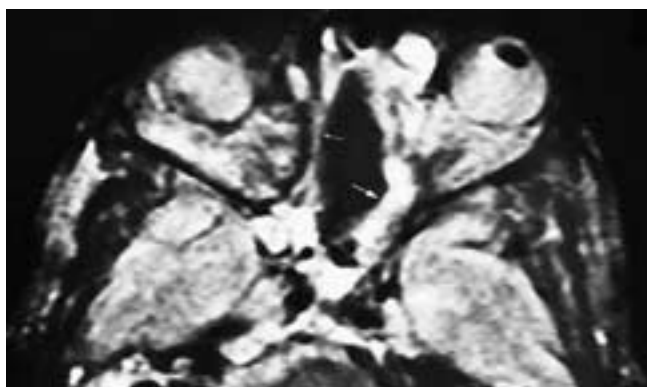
Axial T2-weighted MR image shows the appearance of prior complete bilateral internal ethmoidectomies. Part of the postoperative cavity is lined with fibrotic tissue (*small arrow*), and other areas have inflammatory tissue with a high T2-weighted signal intensity (*large arrow*).
